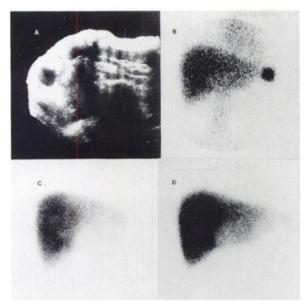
Patient postsplenectomy, with left upper quadrant pain and fever. Transverse ultrasound study (A) reveals left upper quadrant transonic lesion. Indium-111 leukocyte image (B), obtained 18 hr after administration, shows accumulation in area of transonic lesion. Technetium-99m sulfur colloid study 4 mo previously (C) showed no spleen, whereas study performed after leukocyte study (D) revealed new splenic tissue.
